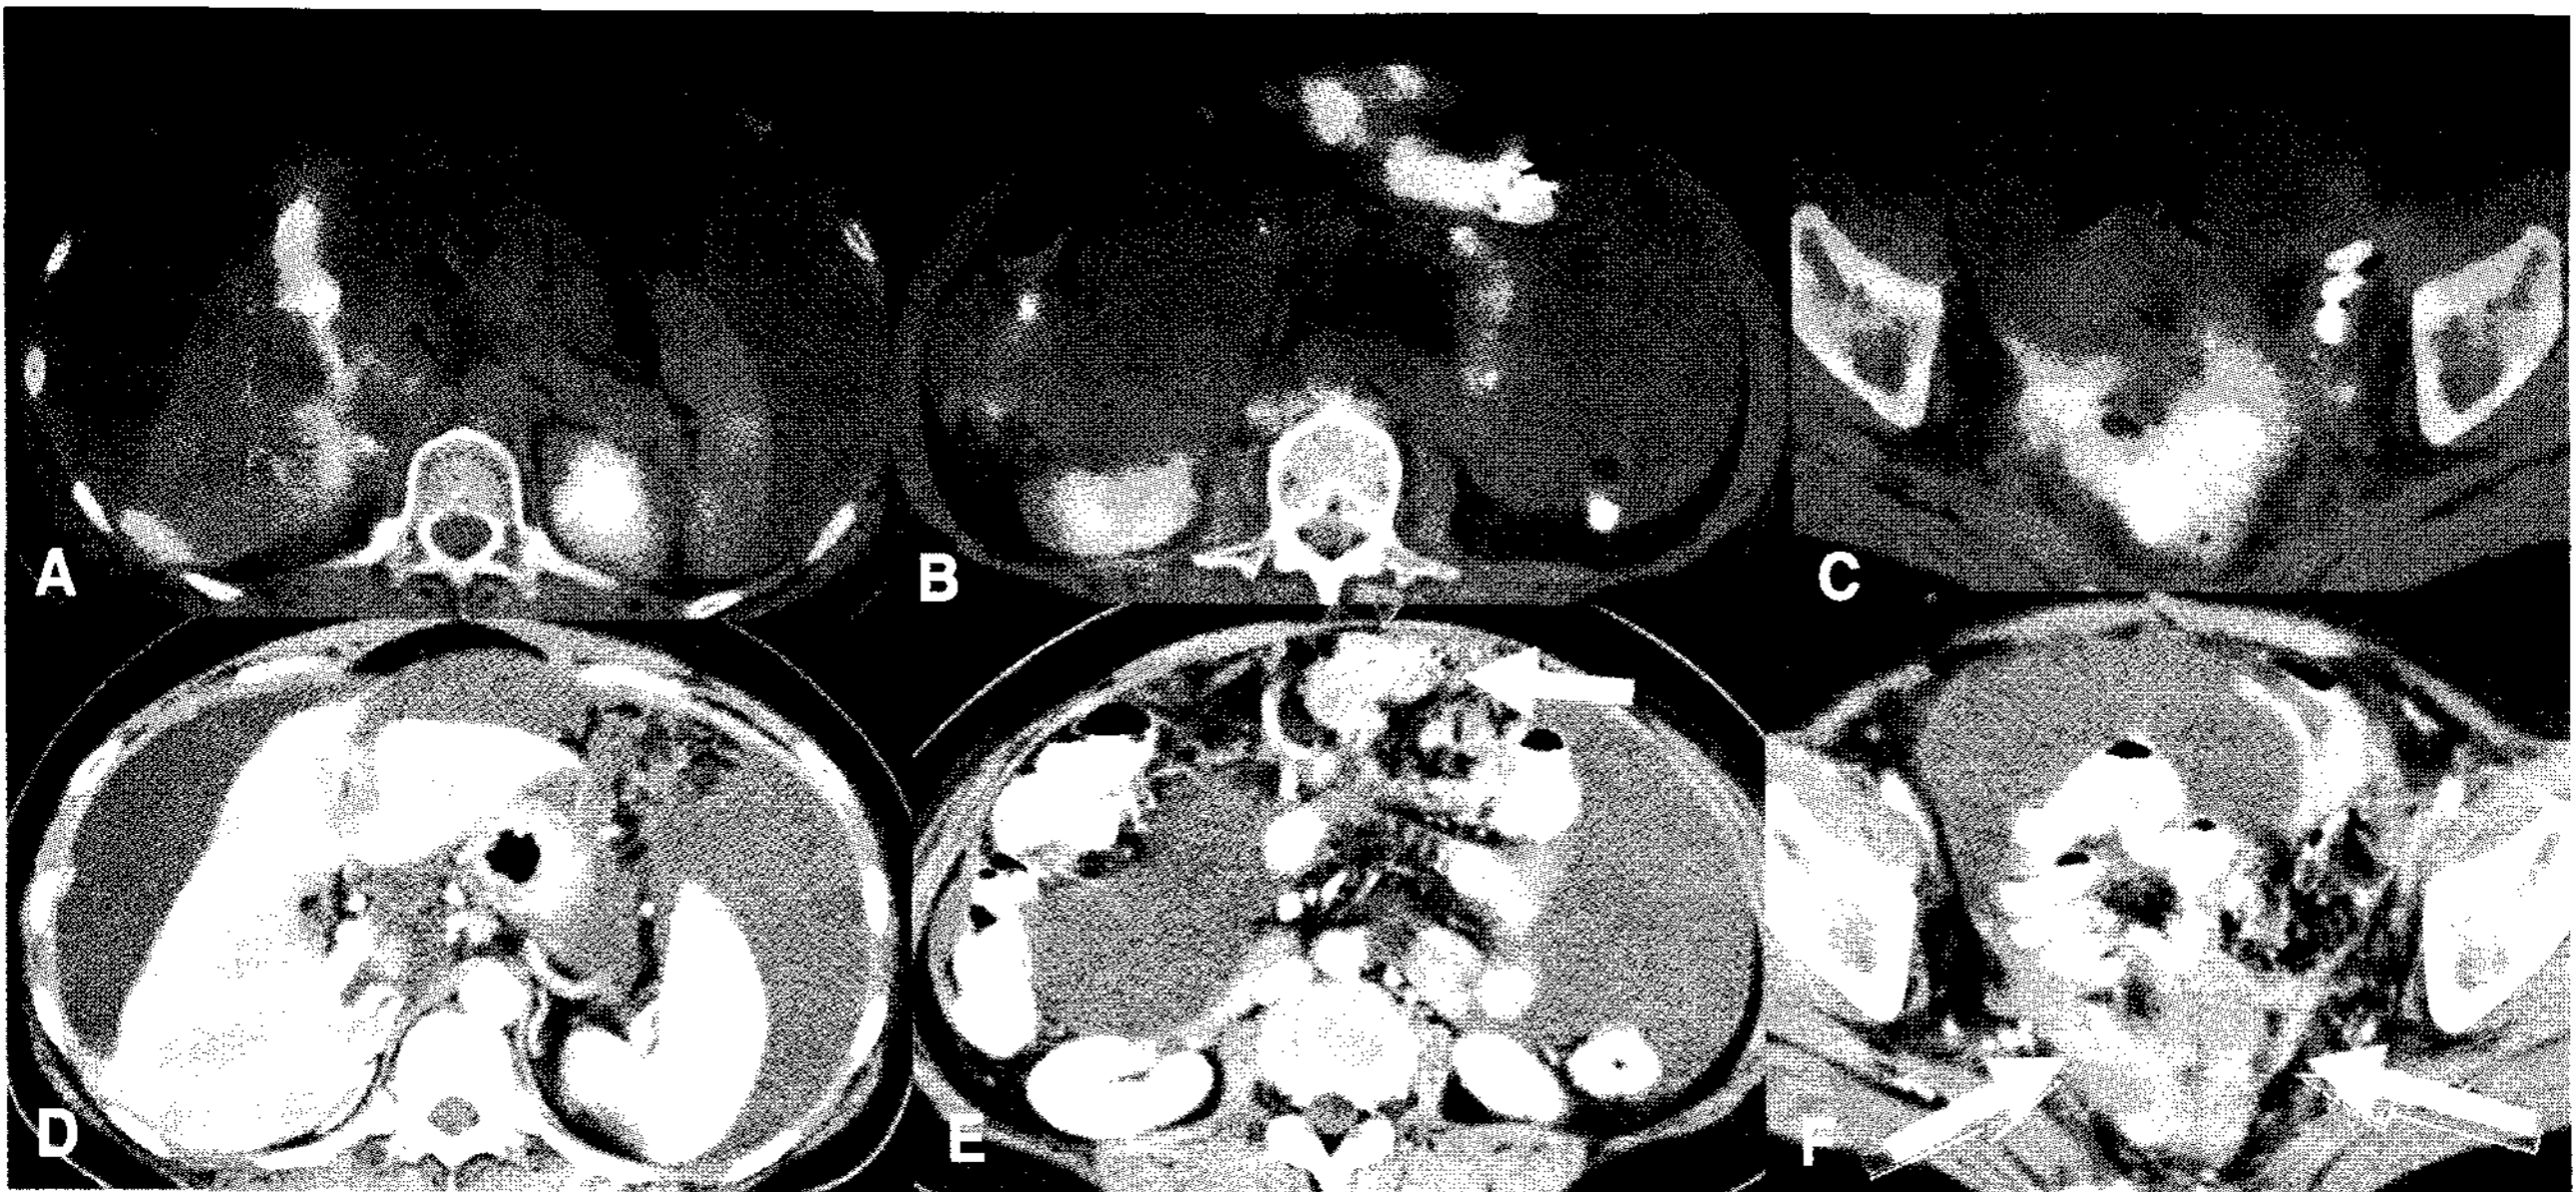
A 53 year old female patient received operation 14 months ago and chemotherapy until 8 months ago for serous cystadenocarcinoma. Fusion images of follow-up PET/CT (A, B, C) show prominent peripheral curvilinear FDG activity along perihepatic area, intense plaque like FDG uptake around the falciform ligament, right paracolic gutter, omentum, mesentery, and pelvic cavity. Enhanced CT (D, E, F) demonstrate findings consistent with carcinomatosis peritonei: massive ascites, irregular shaped soft tissue lesion is seen in greater omentum (arrow), and pelvic cavity lesion encasing sigmoid colon and adjacent small bowel loops (arrows). Tumor marker CA 125 titer was elevated to 1087.60 IU/mL. Ascites fluid cytology was positive for malignant cells and confirmed recurrence.
